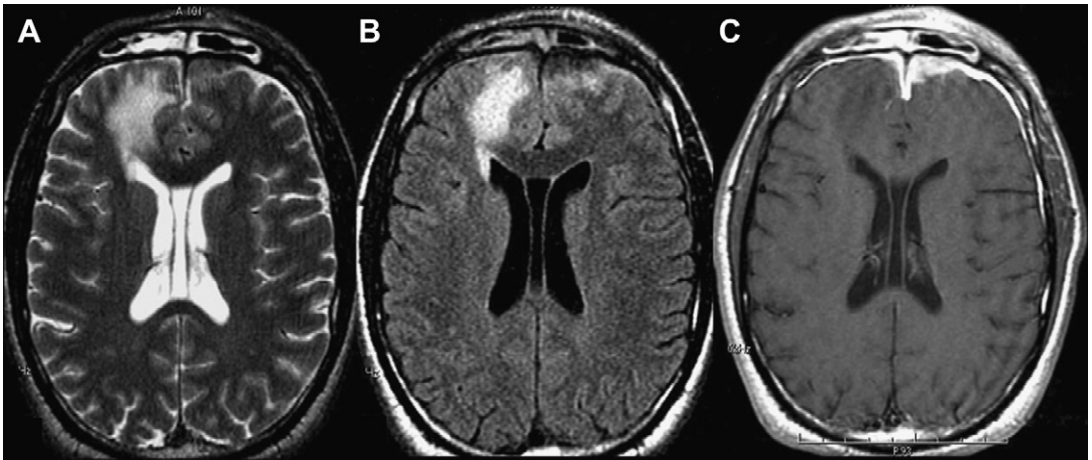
Early cerebritis in a 34-year-old woman with meningitis. Axial T2WI (A) and FLAIR (B) images show focal area of hyperintensity in the right frontal lobe white matter along with the presence of mucosal hypertrophy of bilateral frontal sinuses. Axial postcontrast T1WI (C) shows increased pachymeningeal enhancement in bilateral frontal region, with enhancing mucosal thickening in bilateral frontal sinuses; no abnormal intraparenchymal enhancement was seen.
